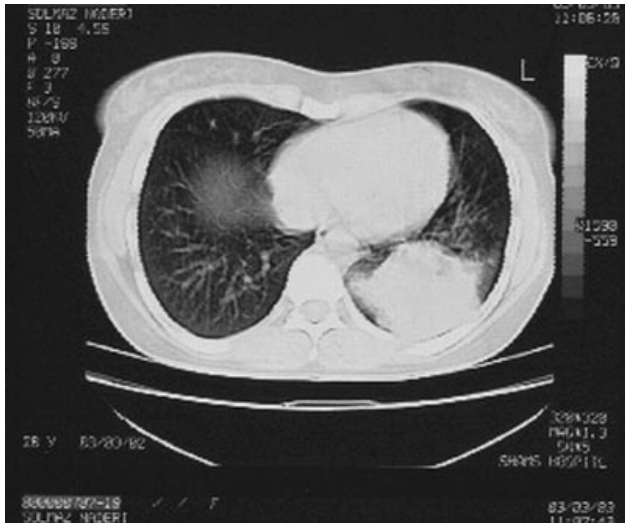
Intralobar pulmonary sequestration. CT scan showing calcified mass in left lower lobe misdiagnosed as a hydatid cyst.
